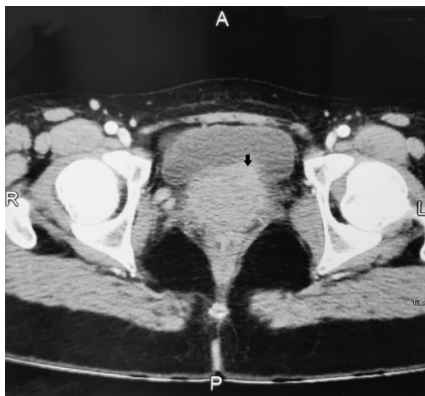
CT scan abdomen and pelvis
